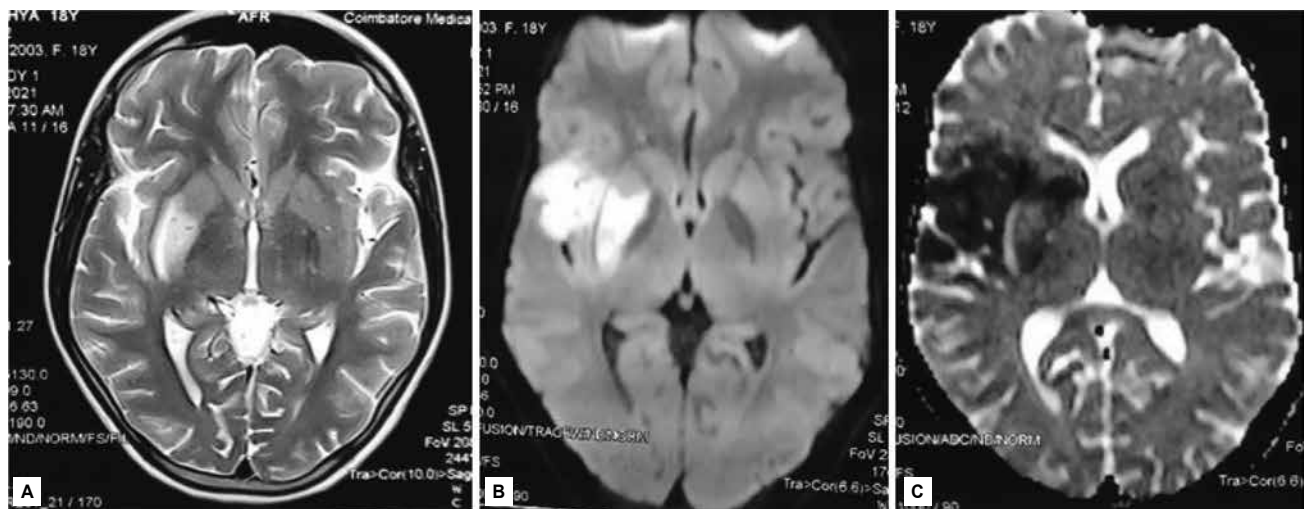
MRI of brain – A) T2/FLAIR; B) Diffusion-weighted imaging showing hyperintensity in right insular cortex and right lentiform nucleus; C) Attenuated diffusion coefficient showing hypodensity in the right gangliocapsular area, right insular cortex and caudate.
